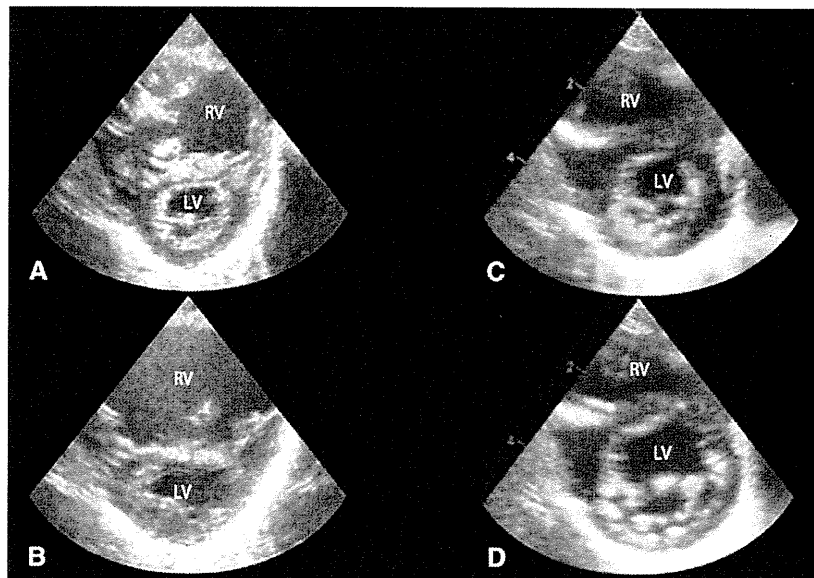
A and B, Preoperative echocardiogram in the end-systolic and end-diastolic phases, respectively (short-axis view). The IVS is shifted toward the LV side by the enlarged RV, especially in the end-diastolic phase. C and D, Postoperative echocardiograms in the end-systolic and end-diastolic phases, respectively (short-axis view). The IVS motion becomes normalized and the LV demonstrates a round shape, thus leading to an increase of the LV volume in the end-diastolic phase. *IVS*, Interventricular septum; *LV*, left ventricle; *RV*, right ventricle.
